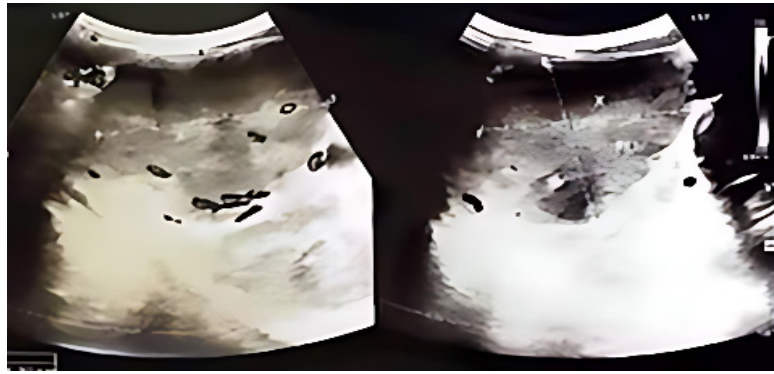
Abdominal ultrasonography showed hypoechoic lesion
